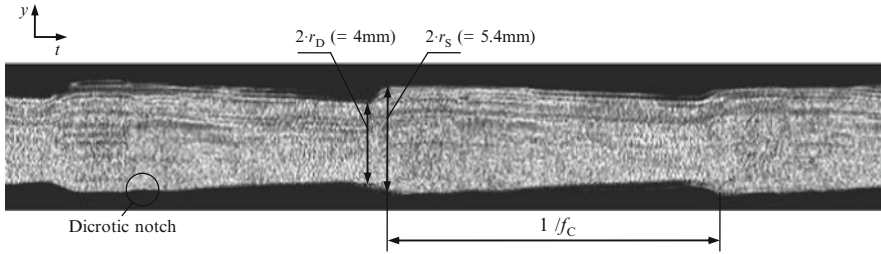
Ultrasonic image (Footnote 215) of the carotid artery in motion mode (Footnote 217). The periodic deflection of the arterial diameter can be observed from its (minimum) diastolic value $2 \cdot r_D$ to its (maximum) systolic value $2 \cdot r_S$, compare Fig. 2.52b
